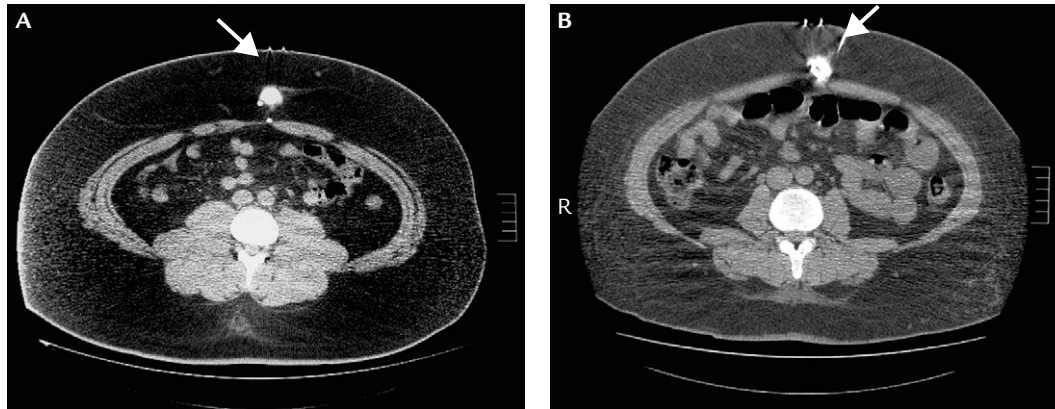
Abdominal computed tomography (CT) shows: (A) subcutaneous injection port floating in the massive subcutaneous fat (arrow); and (B) tilting injection port (arrow). Both cases required CT-guided injection for adjustment.
